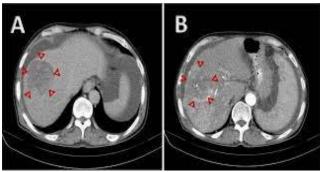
Pathological analysis of hepatic tumors (A) A hypo attenuating nodule is visible on a CT scan obtained during infusion hepatic arteriography. (B) A nodule is visible on a CT scan obtained during arterial portography. Is enhanced in the same way that the hepatic parenchyma is.
